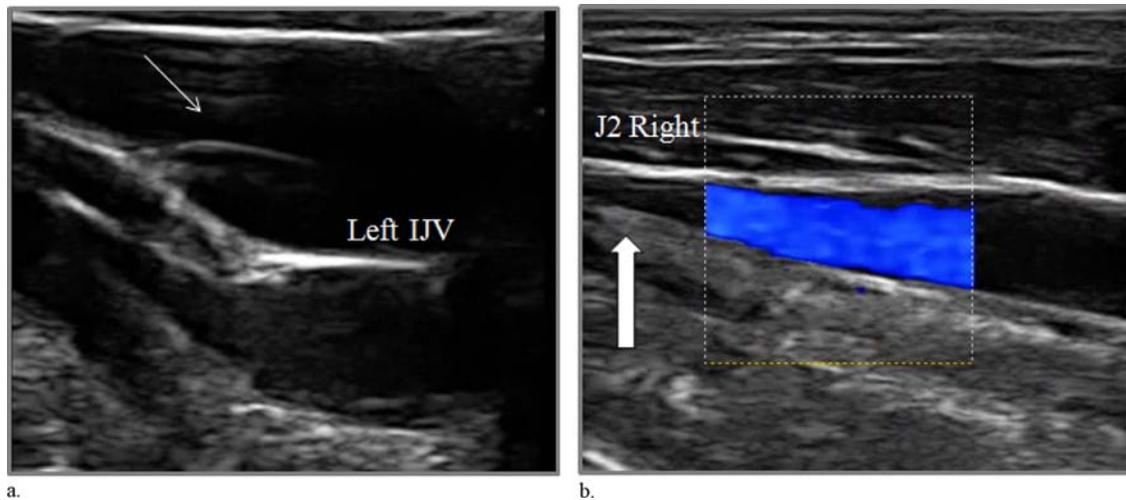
Color Doppler US analysis of the vertebral veins and IJVs, assessing five venous hemodynamic criteria of chronic cerebrospinal venous insufficiency. (a) Immobile septum in the J1 segment of the left IJV (arrow). (b) Annulus constriction in the J2 segment of the right IJV (arrow).
